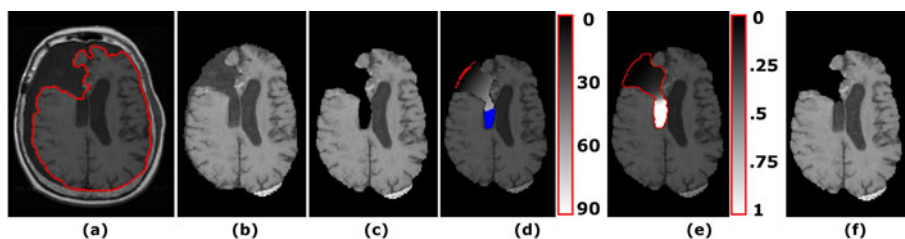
Outline of the proposed algorithm. a) Axial slice of a T1 MRI with a resection cavity. b) Output from ROBEX, which leaves the cavity in the segmentation. c) Output from adaptive thresholding. d) Constrained distance transform within cavity/ventricle (in mm) and resulting seeds for Random Walker (positive in blue, negative in red). e) Probability map from Random Walker within the cavity/ventricle (marked in red). f) Final output, obtained by thresholding e).
